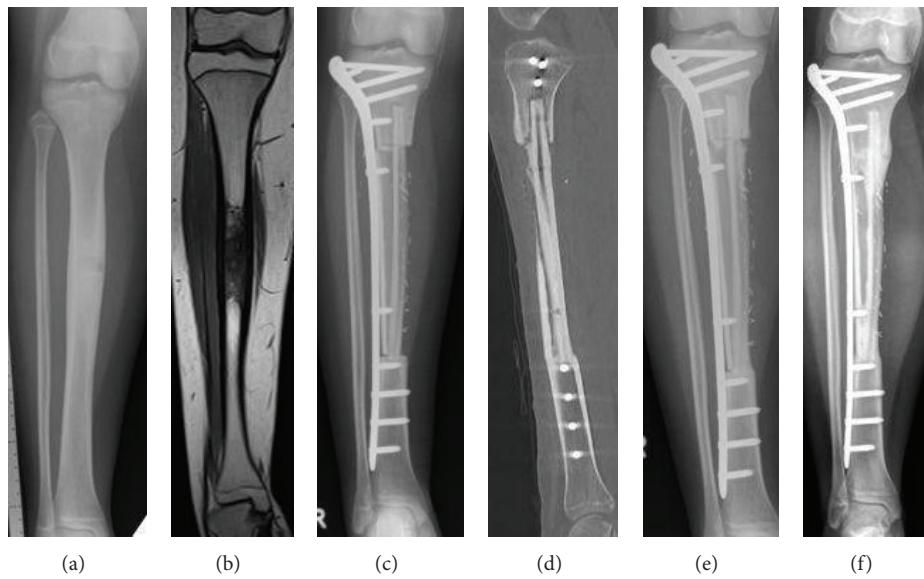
X-ray, CT and MRI imaging in a 14-year-old female patient with Ewing's sarcoma of the right tibia: before operation (a)-(b); three months after operation (c), seven months after operation: no consolidation at the proximal graft host junction (d)-(e); 21 months after operation: fully integrated fibula; and allograft (f).
